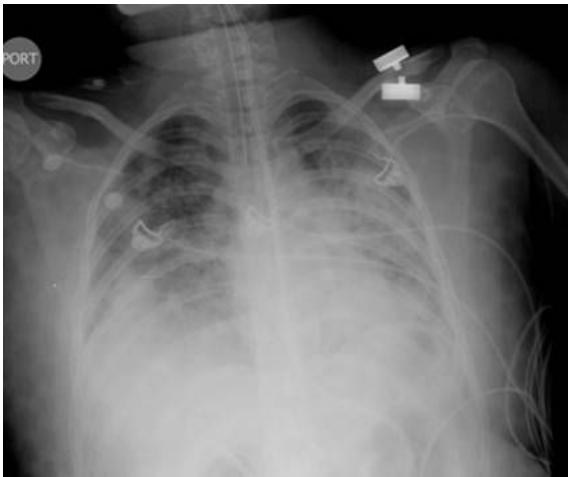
chest xray on second day of admission
